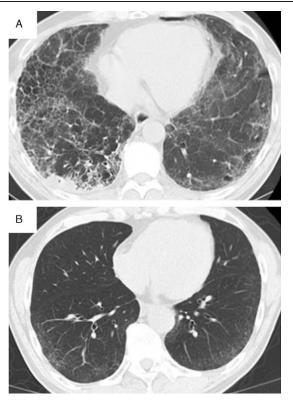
Representative computed tomography findings of lung fibrosis. (A) Distribution throughout entire lung. Fibrosis has extended to inner two-thirds of lung. (B) Peripheral distribution. Fibrosis is localized to only outer third of lung.
